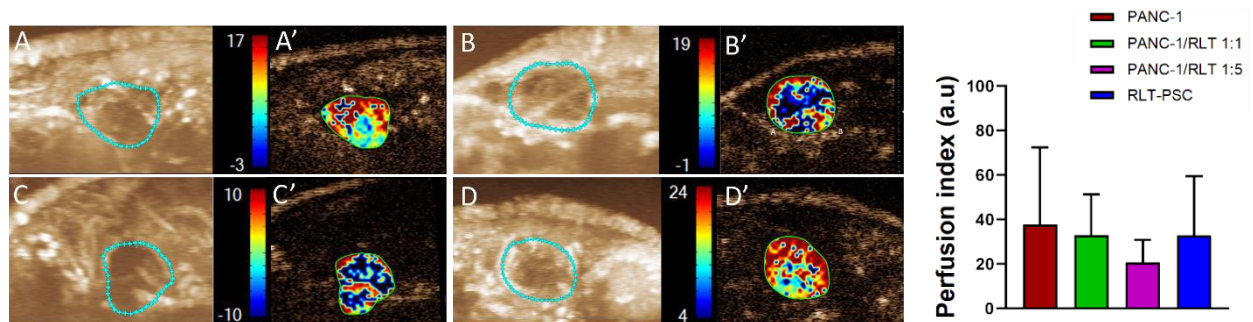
Tumor perfusion index: The maximum intensity projection (MIP) on representative tumors produced from the injection of PANC-1 (A), PANC-1/RLT-PSC 1:1 (B), PANC-1/RLT/PSC 1:5 (C), and RLT-PSC (D) cells was acquired using contrast-enhanced ultrasonography (CEUS) following the injection of microbubble contrast agents (Vevo MicroMarker). (A-D) The spatial distribution of microbubbles on sample tumors is depicted in parametric pictures. The region of interest (ROI) drawn around the periphery of each tumor has been used to compute the PI.
